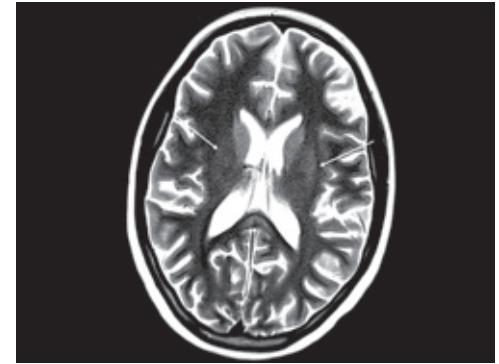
Axial T2-weighted image shows patchy but symmetrical T2 hyperintensity involving the deep white matter and splenium of the corpus callosum.
